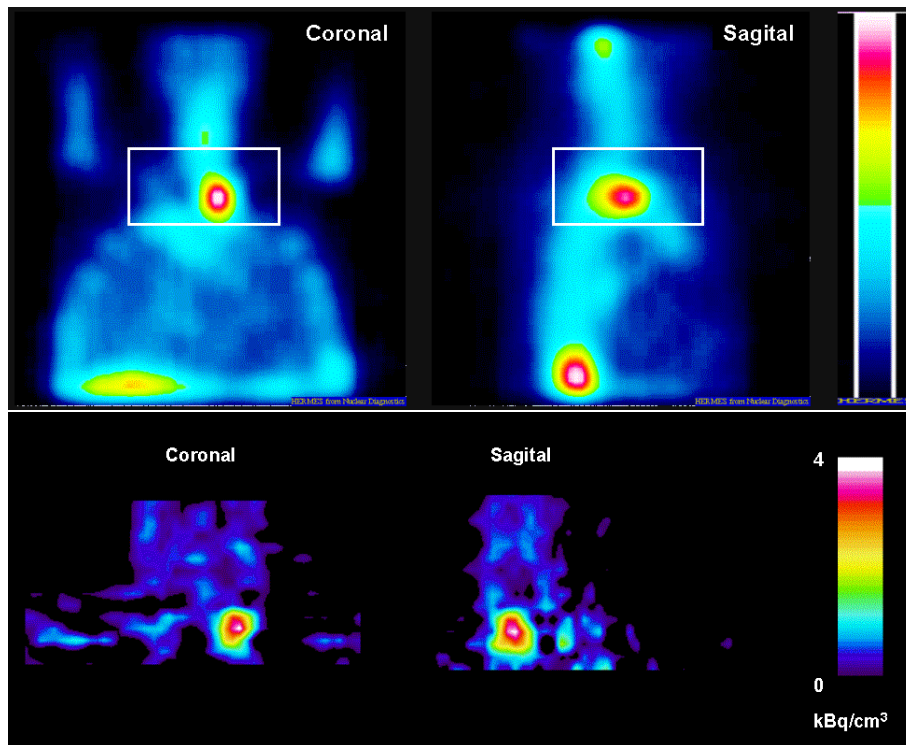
Top: reoriented SPECT images, 24 h after administration of 175 MBq of ^{111}In -octreotide. The rectangles in the images indicate the position of the PET images. Bottom: PET images of the same patient, 1.5 h after administration of 140 MBq $^{110\text{m}}\text{In}$ -octreotide.*
